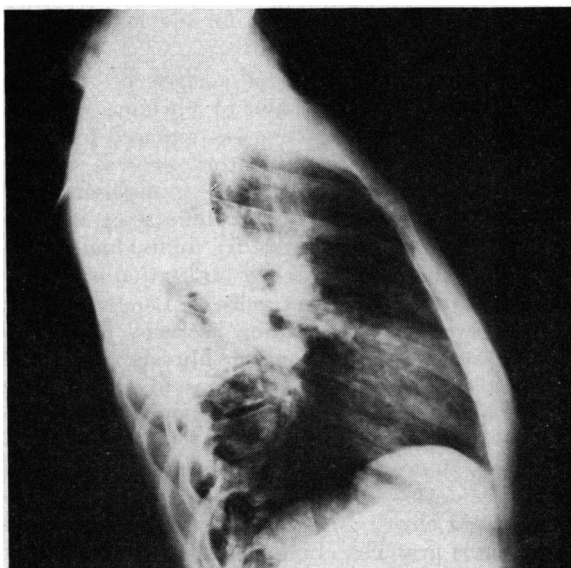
Right lateral chest roentgenogram obtained on June 11, 1959. This film shows the distribution of the infiltrates and the apparently normal upper mediastinum.
